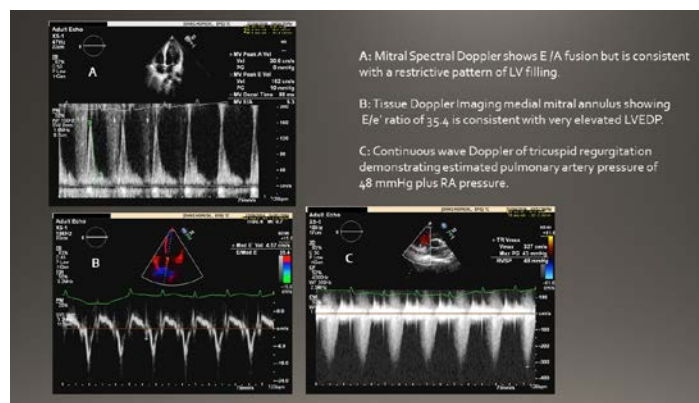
Echo Doppler findings at presentation. Panel A: pulsed Doppler mitral inflow. Panel B: tissue Doppler septal annulus. Panel C: continuous wave Doppler tricuspid valve
